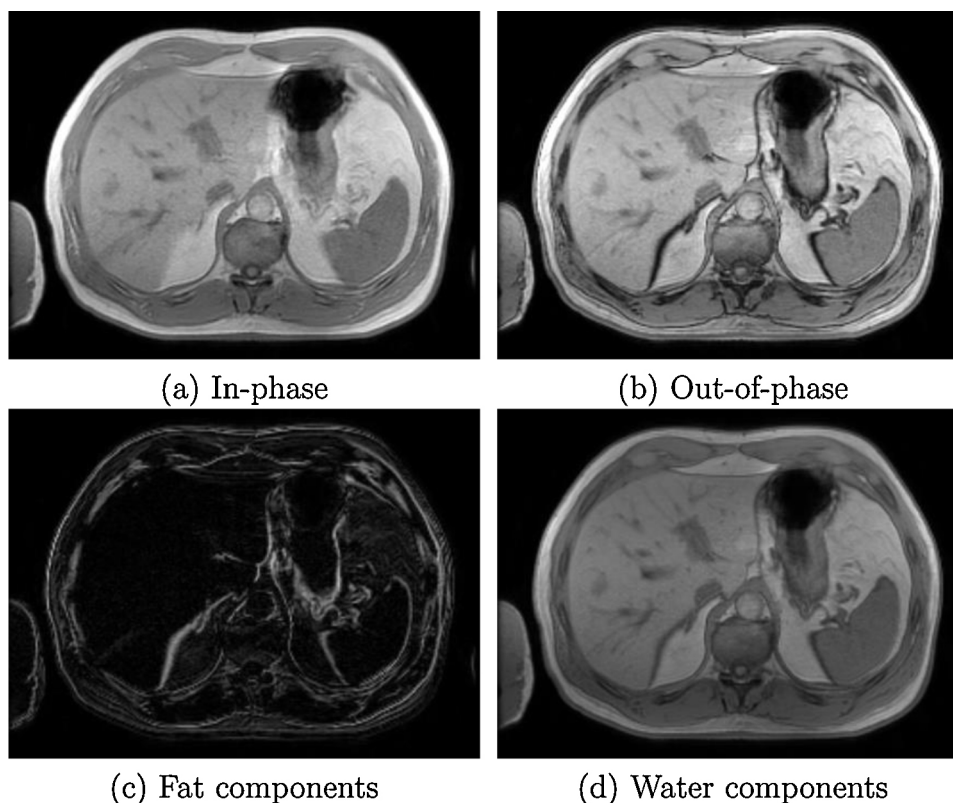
Dual-phase MRI and fat/water separation.
